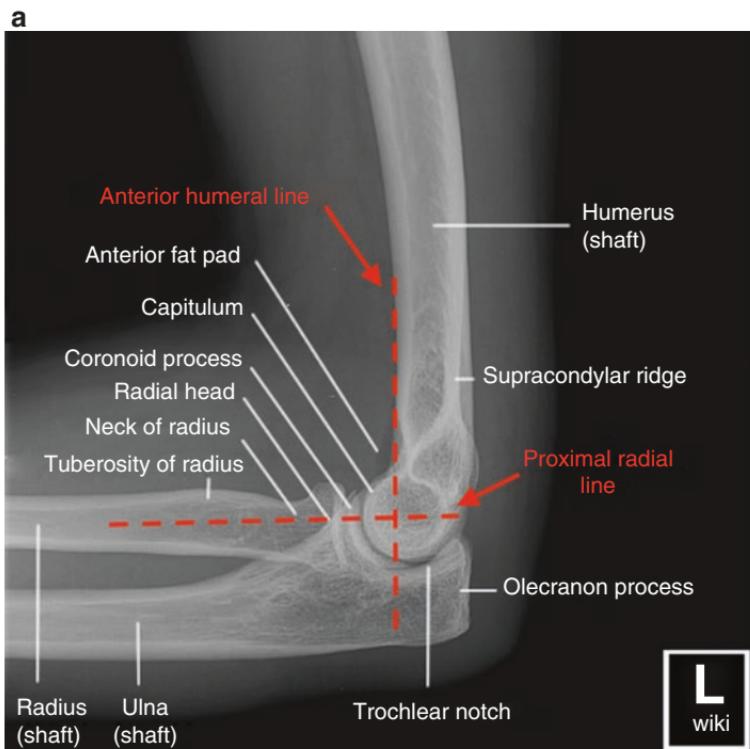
(a) Annotated lateral elbow X-ray with depiction of anterior humeral and proximal radial line, (b) joint movement pivots around the intersection of these lines. (a: Reprinted with permission from [wikiRadiography.net](http://www.wikiradiography.net/page/Elbow+Radiographic+Anatomy): <http://www.wikiradiography.net/page/Elbow+Radiographic+Anatomy>. b: Reprinted from Haugstedt J. Dissociations of the Radius and Ulna: Surgical Anatomy and Biomechanics. In: Berger RA, Weiss APC (eds). Hand Surgery. Philadelphia: Lippincott Williams & Wilkens; 2004. With permission from Wolters Kluwer Health)
